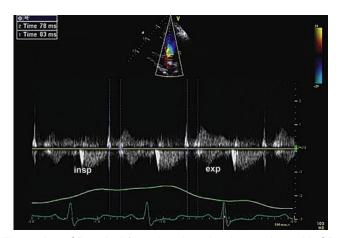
CP: apical four-chamber view in a patient with CP. The isovolumic relaxation time (IVRT) is obtained by continuous-wave Doppler but can alternatively be obtained with PW Doppler. The IVRT is the time from aortic valve closure to mitral valve opening and can be obtained in inspiration and expiration. Typically, the IVRT of the left ventricle will increase with inspiration; in this example, 83 msec in inspiration and 78 msec in expiration.
